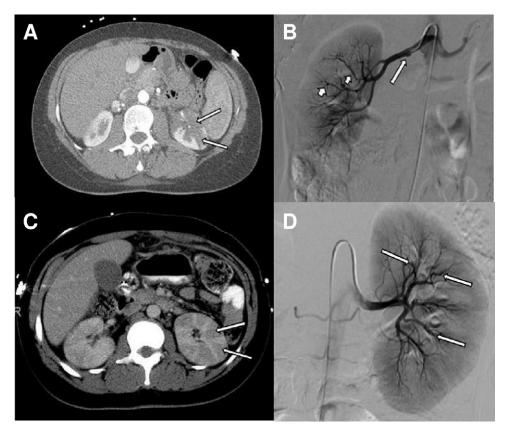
Radiologic images of patients (A, B) 1 and (C, D) 2. Patient 1: (A) contrast-enhanced computed tomographic scan of the abdomen shows wedge-shaped infarcts involving the left kidney (arrows), and (B) selective right renal arteriogram shows focal dissection of the main renal artery (long arrow) and microaneurysms (large arrowhead) and fusiform aneurysms (small arrowhead) of interlobular arteries. Patient 2: (C) bilateral striated renal cortical nephrograms with wedge-shaped areas of hypoattenuation (arrows) compatible with renal infarcts, and (D) selective left renal arteriogram shows abrupt occlusion of multiple interlobular arteries (arrows) compatible with thrombosis.
